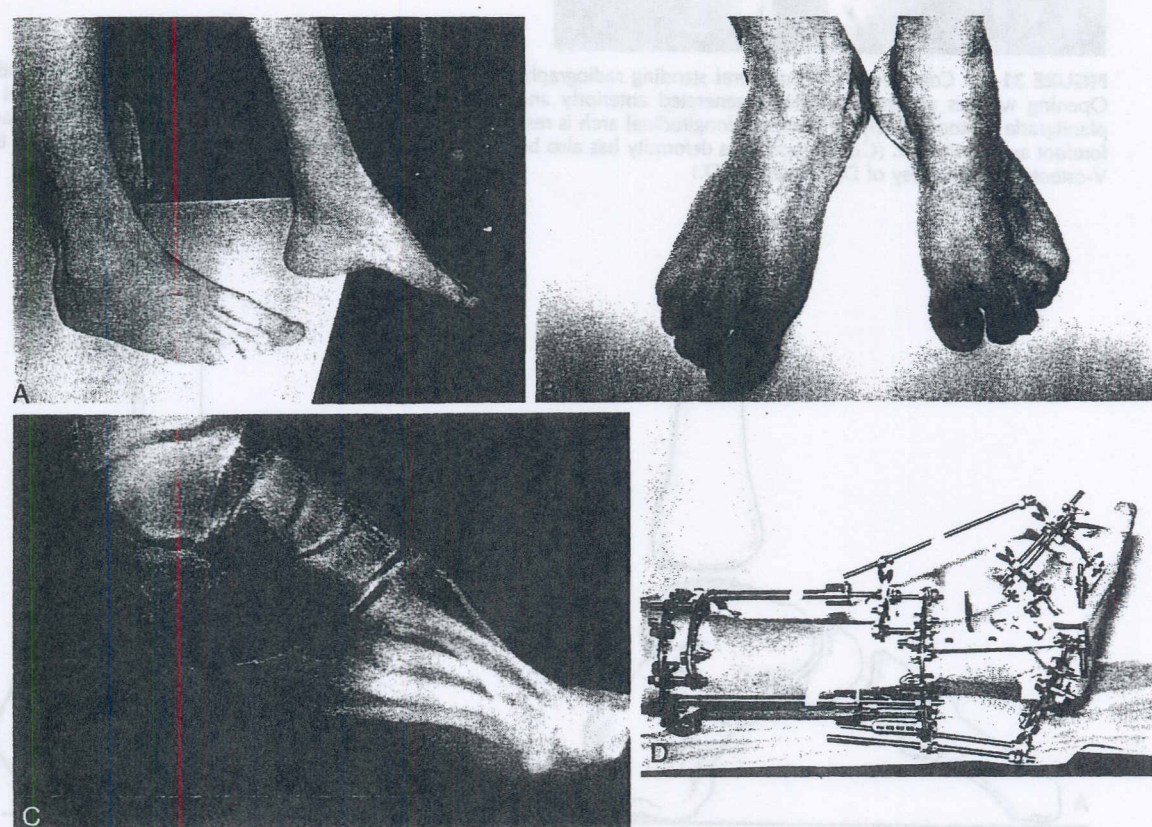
(A), A 16-year-old boy with residual clubfoot deformity; he has hindfoot equinus and forefoot cavus to different degrees. (B), His foot also has an adductus deformity. (C), The lateral radiograph demonstrates a flat-top talus. A V-osteotomy was performed to correct the hindfoot and forefoot deformities independently. The V-osteotomy can be seen on the radiograph before application of the apparatus. (D), The apparatus is quite complex. The anterior and posterior hinges are marked with asterisks. The tibia was simultaneously lengthened.
